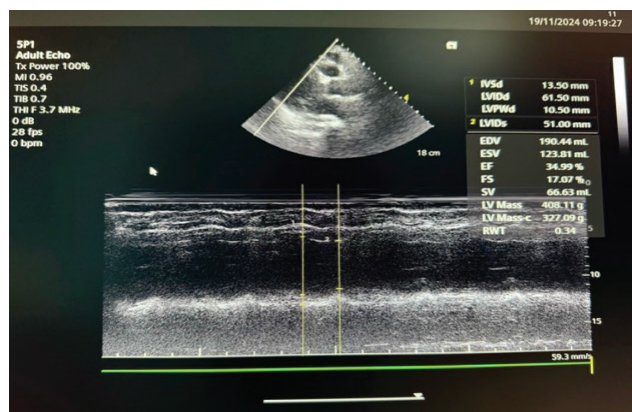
Echocardiography of the patient 1 day before discharge.
